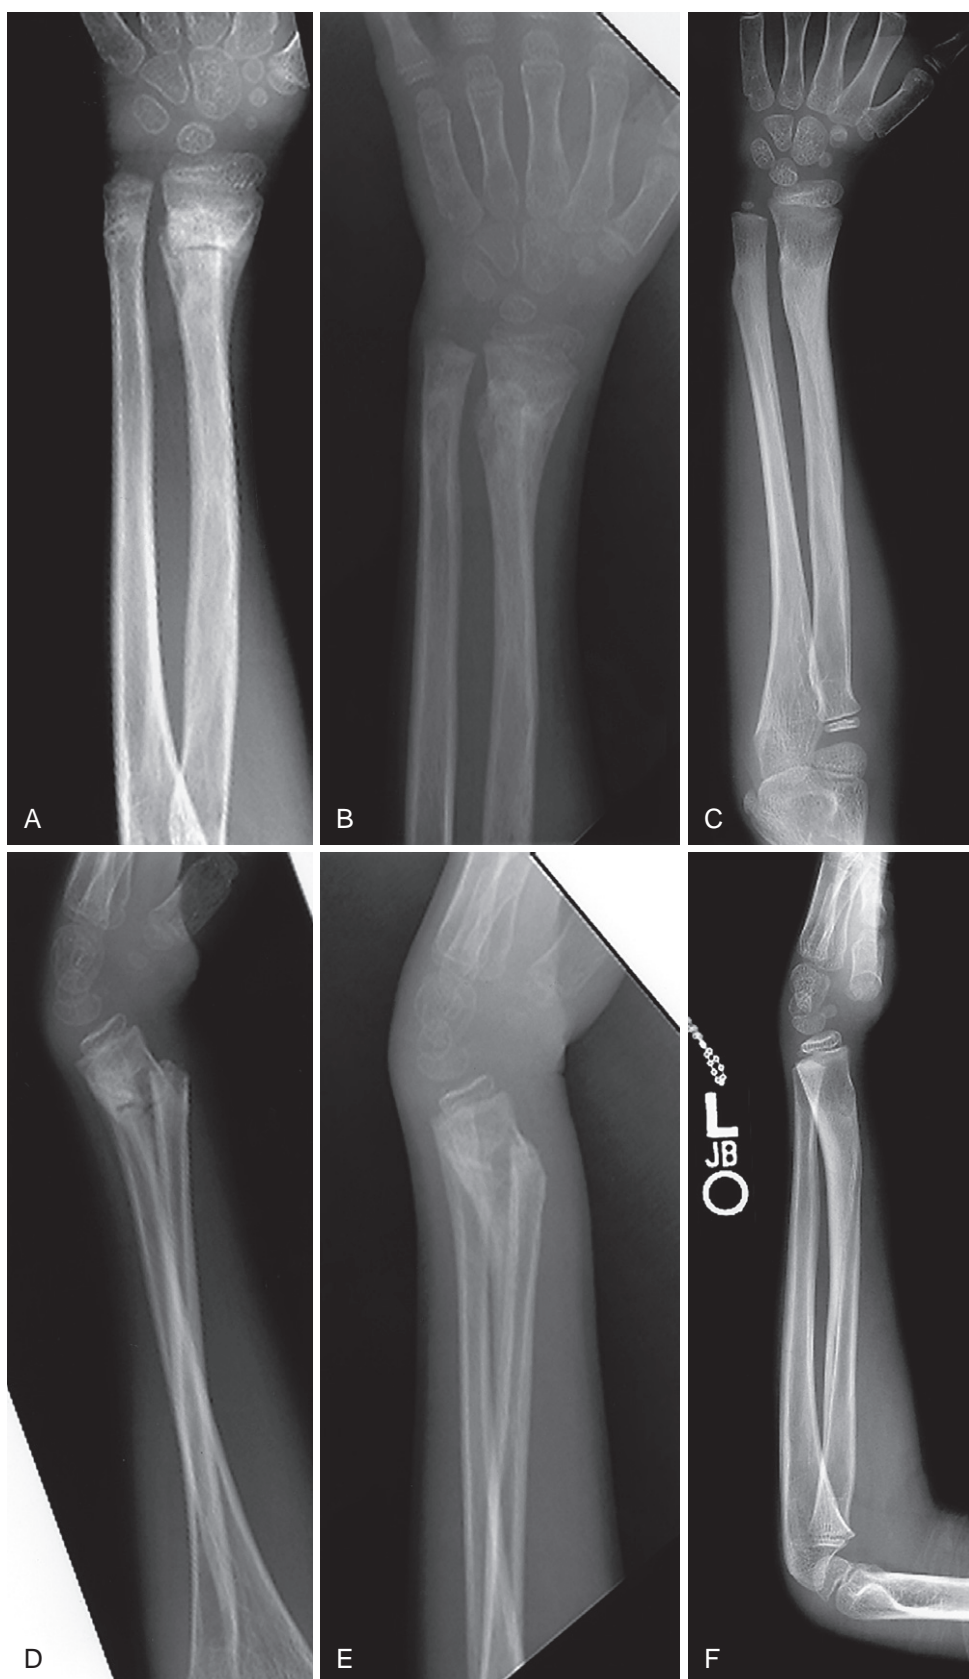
Forearm radiographs of a 7-year-old boy demonstrating remodeling of a forearm fracture over a 9-month period. A to C, Anteroposterior plane. D to F, Lateral plane.
